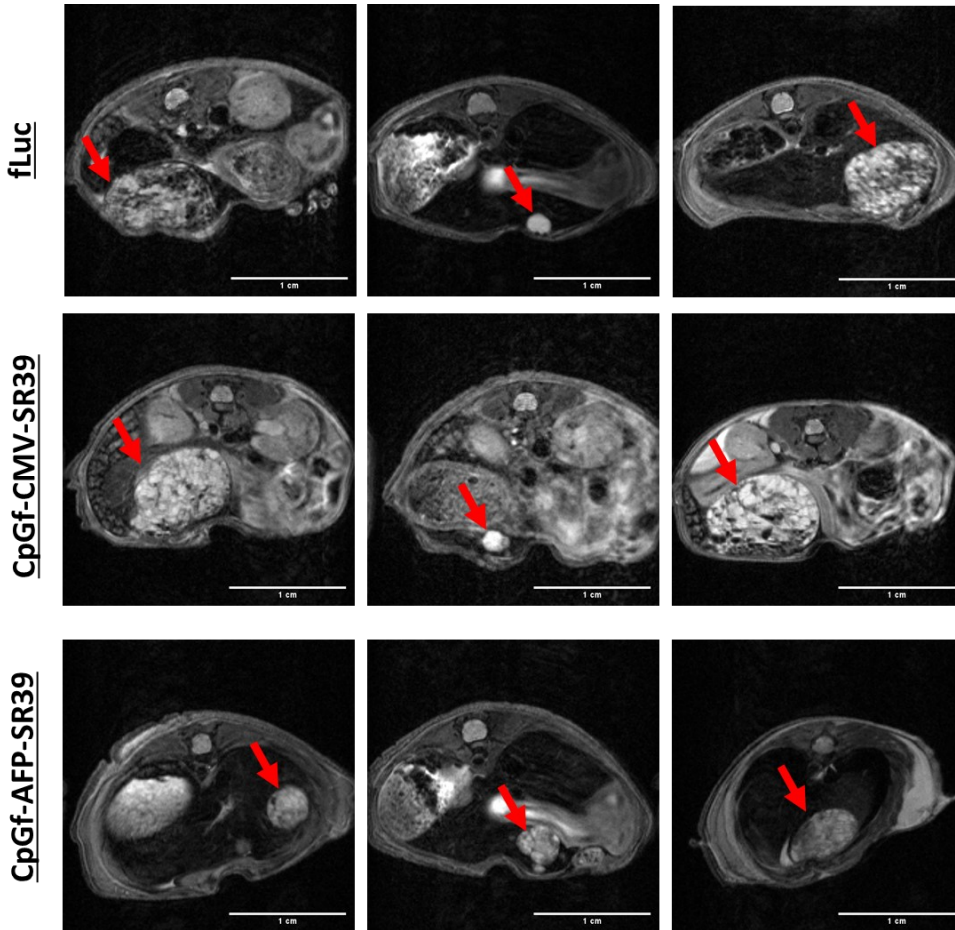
T2-weighted MRI scans of the liver and HCC tumors on Day 16. Arrows point to hyperintense tumors. Scale bar = 1 cm.
